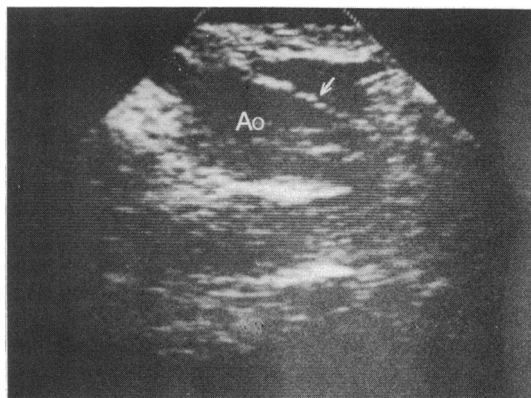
An echocardiogram in case 57 suggesting the presence of dissection of transverse aorta. Dissection was excluded at angiography and at surgery. Arrow indicates the line responsible for the misinterpretation. Ao, aorta.
